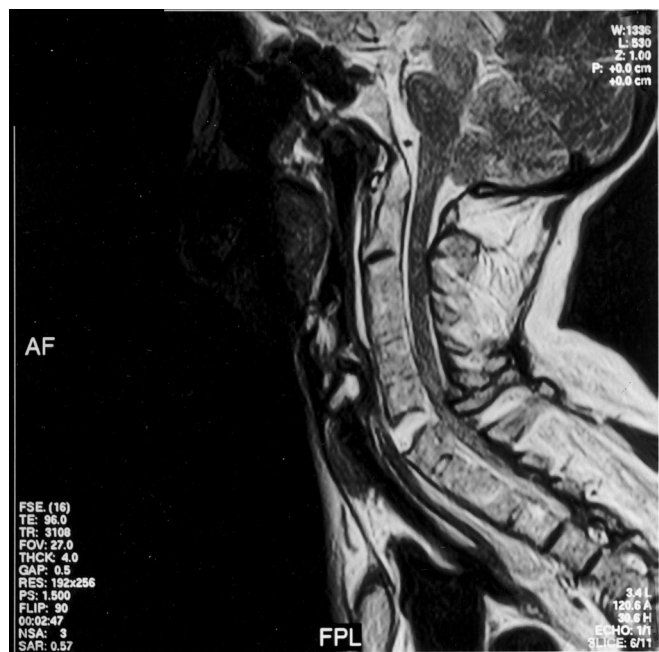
This 60-year-old who had a fixed downward gaze because of ankylosing spondylitis suffered a fall. Initial radiographs showed details up to C4. Pulled lateral radiographs showed details up to C6 body only. During MRI scan evaluation, the unsupported head gradually extended to result in C6/7 complete tetraplegia.
